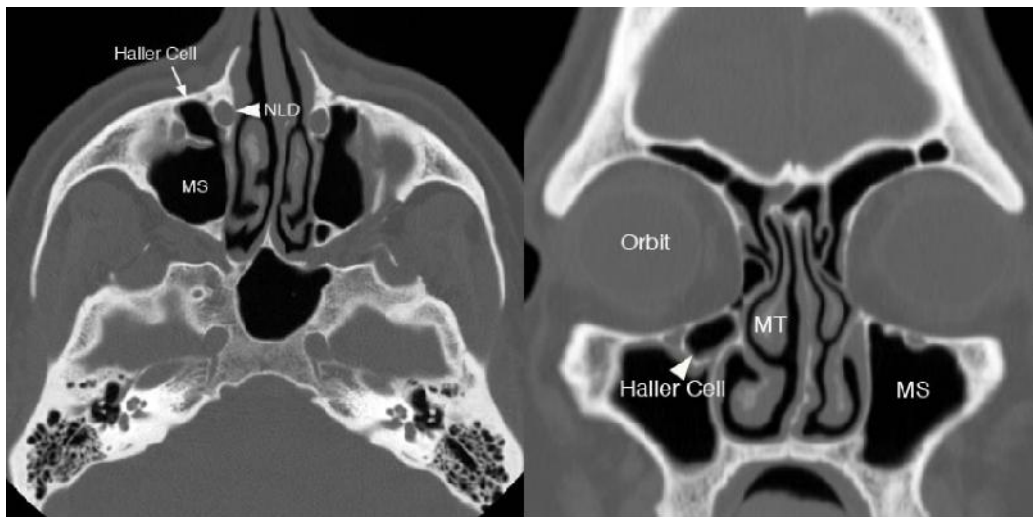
Axial and Coronal CT images showing Haller Cell (Infraorbital air cells)
